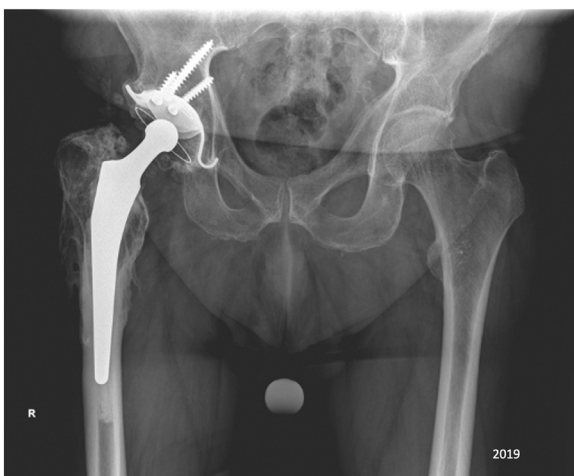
Anteroposterior radiograph in 2019 (latest radiographic follow-up) demonstrating well-fixed components. No loosening visible of either component.
